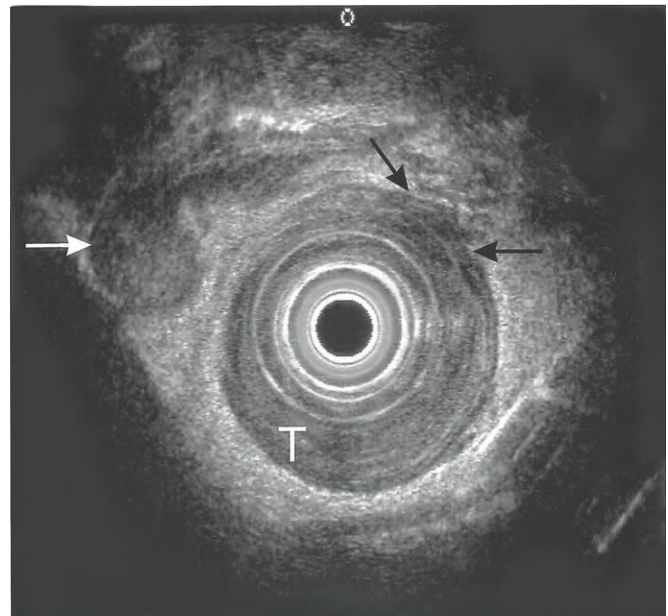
T3 N1 esophageal carcinoma. *Upper*, A T3 tumor (T) obliterates the ultrasound anatomy at this level. At 1 o'clock (*black arrows*), the tumor breaks through the fourth ultrasound layer and invades the fifth. An N1 regional lymph node (*white arrow*), close to the primary tumor, is large (2.2 cm in diameter), round, hypoechoic, and sharply demarcated. *Lower*, A T3 N1 tumor breaches the muscularis propria to invade periesophageal tissue and metastasizes to a regional lymph node.
